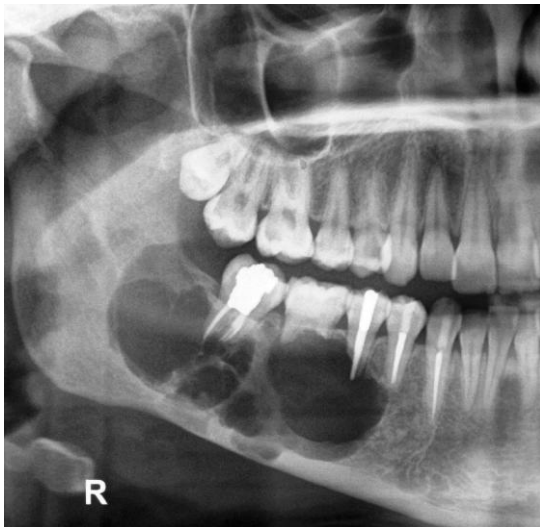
The panoramic radiograph revealed a well-defined corticated multilocular radiolucent lesion with coarse and curved internal septa and root resorption of #45, #46
